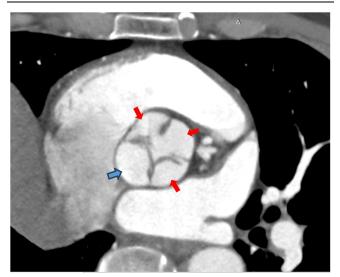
Computed tomography (CT) coronary angiography axial image showing a quadricuspid aortic valve. Note that the aortic cusps are of different sizes, with one larger (blue arrow) than the other three cusps (red arrow), which are of similar size.
